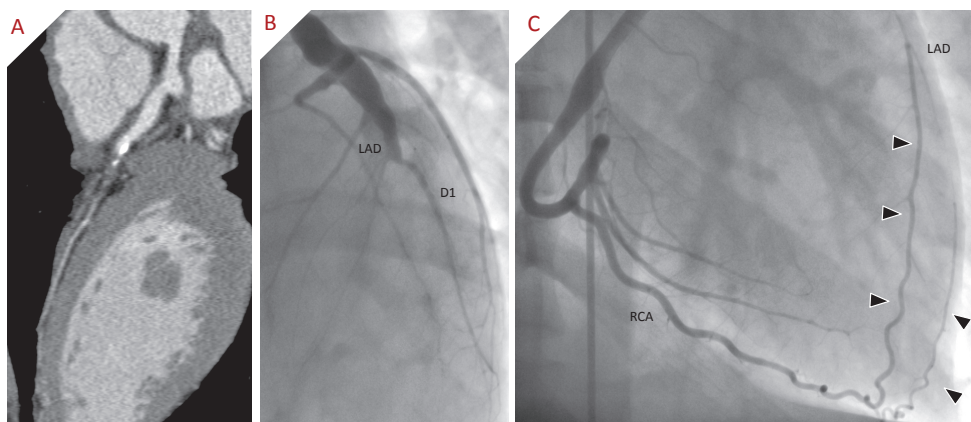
Computed tomography angiography in a 20-year-old male known with Kawasaki disease. Multislice computed tomography was performed for follow-up of known dilated coronary arteries. (A) multiplanar reconstruction of the LAD shows a dilated proximal part of the coronary artery with a totally occluded segment beyond a calcified plaque. (B) Distally the coronary artery is small in diameter. Invasive coronary angiography shows an aneurysmatically dilated LAD with a chronic total occlusion at the site where the first diagonal branch splits from the LAD. (C) Extensive collaterals (arrowheads) from the right coronary artery allow filling the distal LAD with contrast. D1: First diagonal branch; LAD: Left anterior descending coronary artery; RCA: Right coronary artery.
